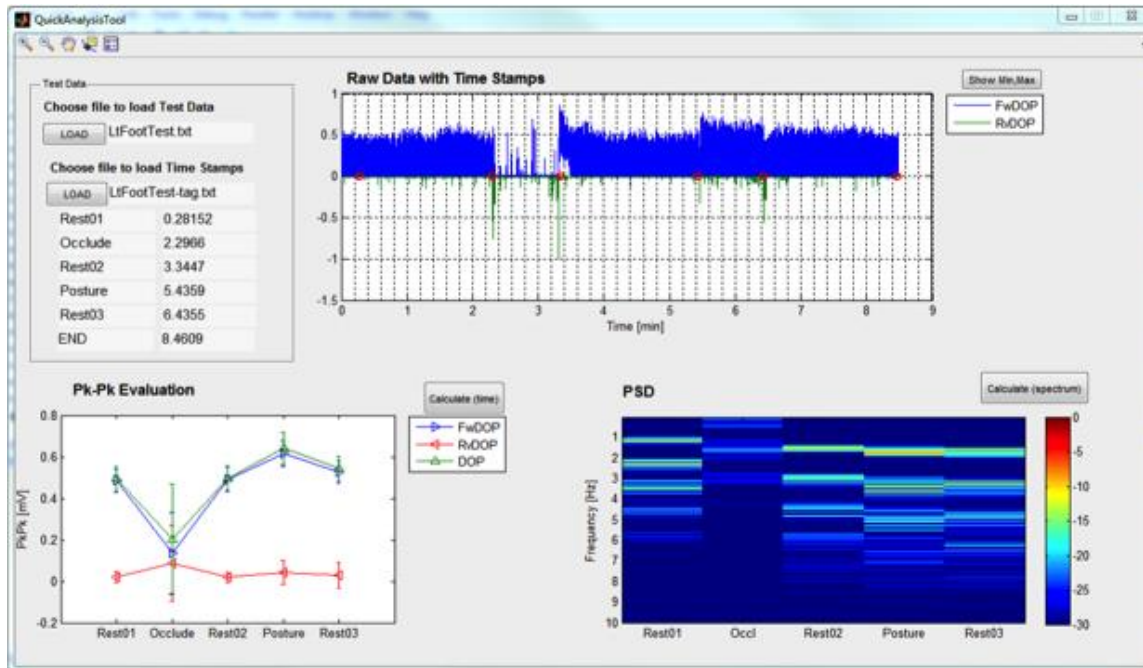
Doppler Project Quick Analysis Tool GUI.
